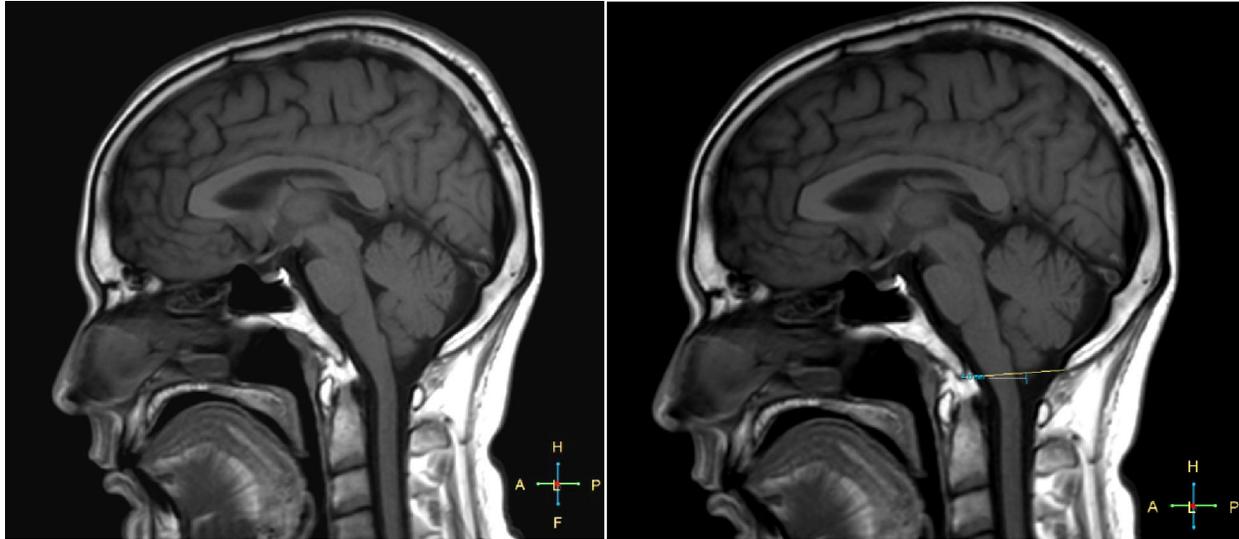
T1 weighted midsagittal MRI of a 35 years old patient before and after measurement of the degree of descent of the posteroinferior cerebellar lobe. The horizontal line indicates the basion-opisthionline. The position of the tip of the posteroinferior cerebellar lobe is 4 mm below the foramen magnum. The posteroinferior cerebellar lobe is oval shaped rather than having a peg-like configuration.
